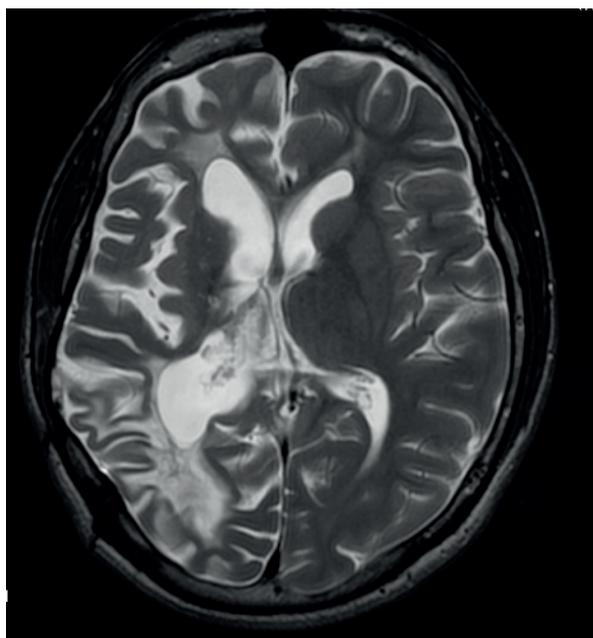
ADEM MRI features
